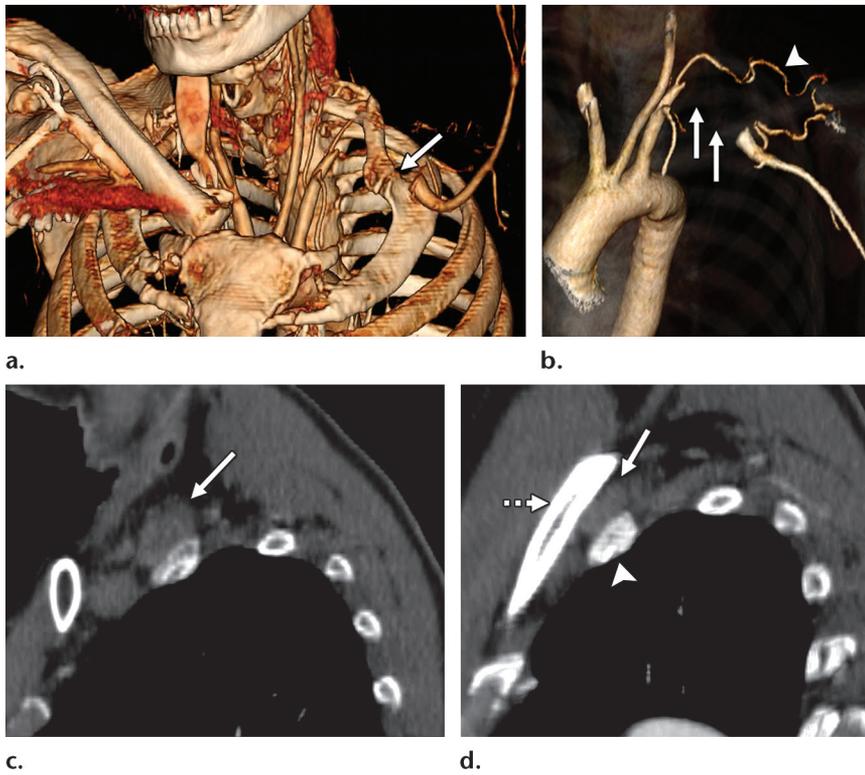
Arterial TOS in a patient with symptoms of arterial insufficiency to the left upper extremity. (a) Volumetric reconstruction from CT shows an anomalous left first rib that is hypoplastic and forms a joint with the second rib (arrow). (b) Volumetric reconstruction from arterial phase CT with the left arm adducted shows an area of thrombosis of the left subclavian artery (arrows) as well as an enlarged collateral (arrowhead). (c) Sagittal arterial phase CT image with the left arm adducted shows the uncompressed left subclavian artery (arrow), which is larger than expected and nonenhancing, consistent with thrombosis. (d) Image with the left arm abducted shows that the clavicle (dashed arrow) has moved posteriorly and compresses the left subclavian artery (solid arrow) against the hypoplastic left first rib (arrowhead). The findings of left subclavian artery thrombosis, enlargement, and dynamic compression confirmed the diagnosis of arterial TOS.
